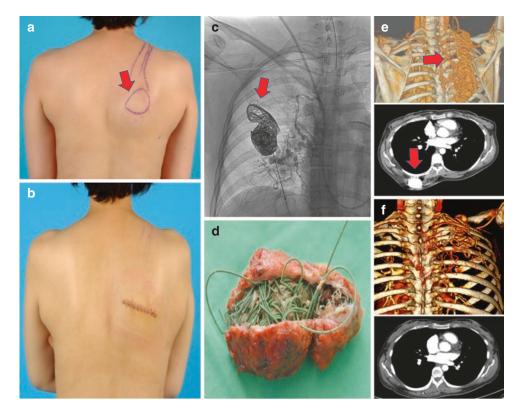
CC: pulsating mass on back. Dx: Arteriovenous malformation. (a) preop picture. (b) postop picture. (c) coil embolization. (d) op finding: AVM mass and coil within the mass. (e) preop CTA. (f) postop CTA
